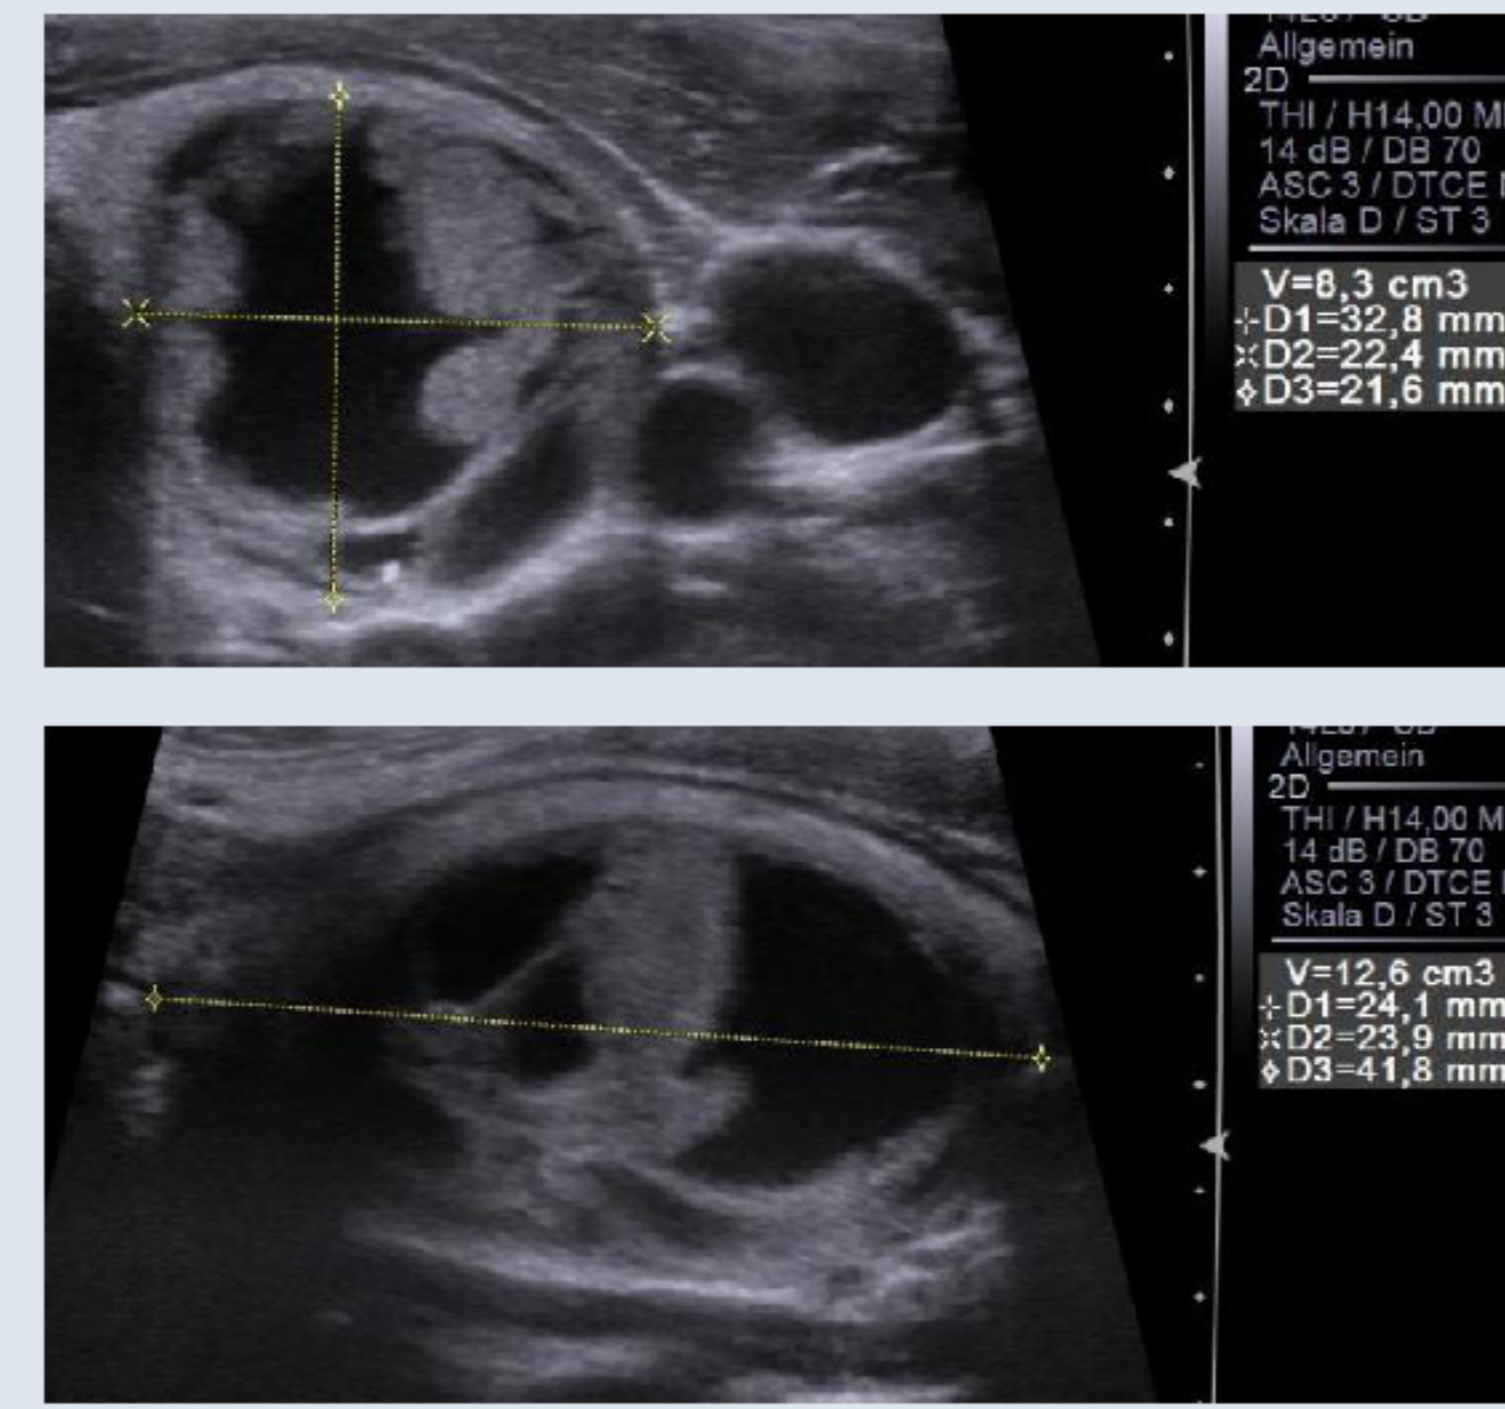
Thyroid Ultrasonography, left lobe
